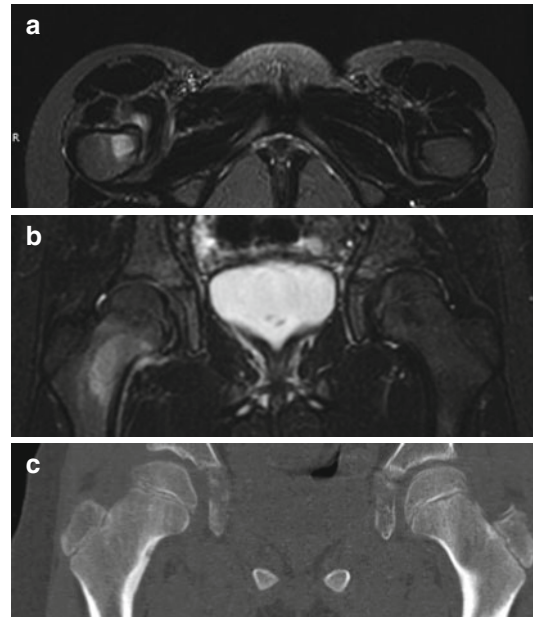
An osteoid osteoma of the femoral neck in an 8-year-old girl with a 2-month history of right thigh and groin pain without any fevers. It was relieved by NSAIDs. Axial (a) and coronal (b) MRI sequences demonstrate the intense inflammatory response. Coronal CT scan reconstruction demonstrates the cortical thickening around the lucent lesion with its small ossific nidus (c)
